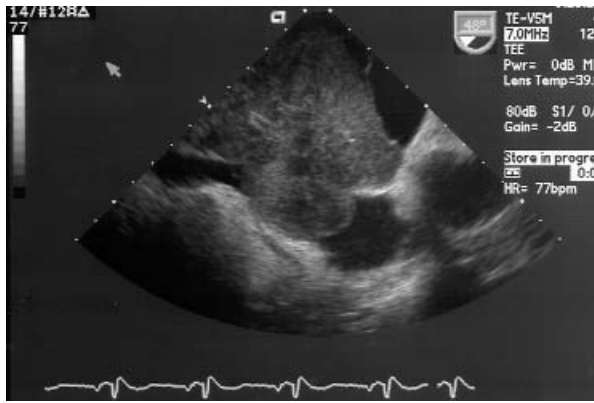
Transesophageal echocardiogram shows a tumor occupying the atrium.
